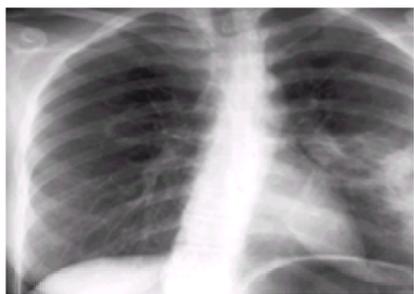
Wegener's granulomatosis. PA chest radiograph demonstrates dense focal alveolar infiltrates in an 18-year-old female patient with sinusitis, cough, fever, and cutaneous nodules. Serum antineutrophil cytoplasmic antibody was positive (c-ANCA titer of 1:1200). Skin biopsies demonstrated a leukocytoclastic vasculitis. Sinus biopsies revealed a granulomatous necrotizing vasculitis consistent with Wegener's granulomatosis. Chest radiographs normalized within 2 weeks of initiation of cyclophosphamide and prednisone therapy.
